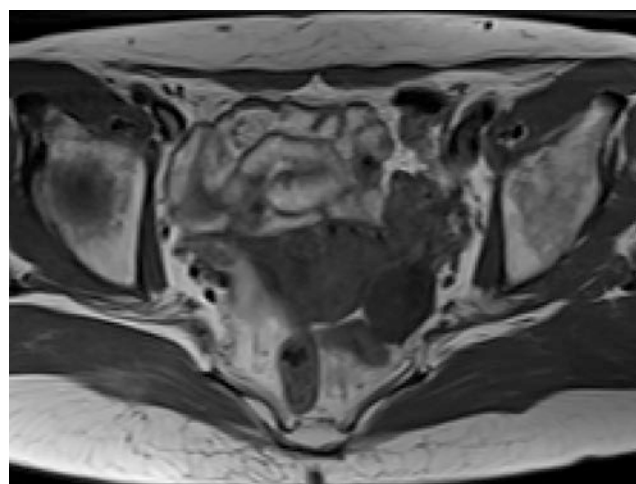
Axial T1-weighted image showed an oval lesion of low signal intensity in the left adnexa area
